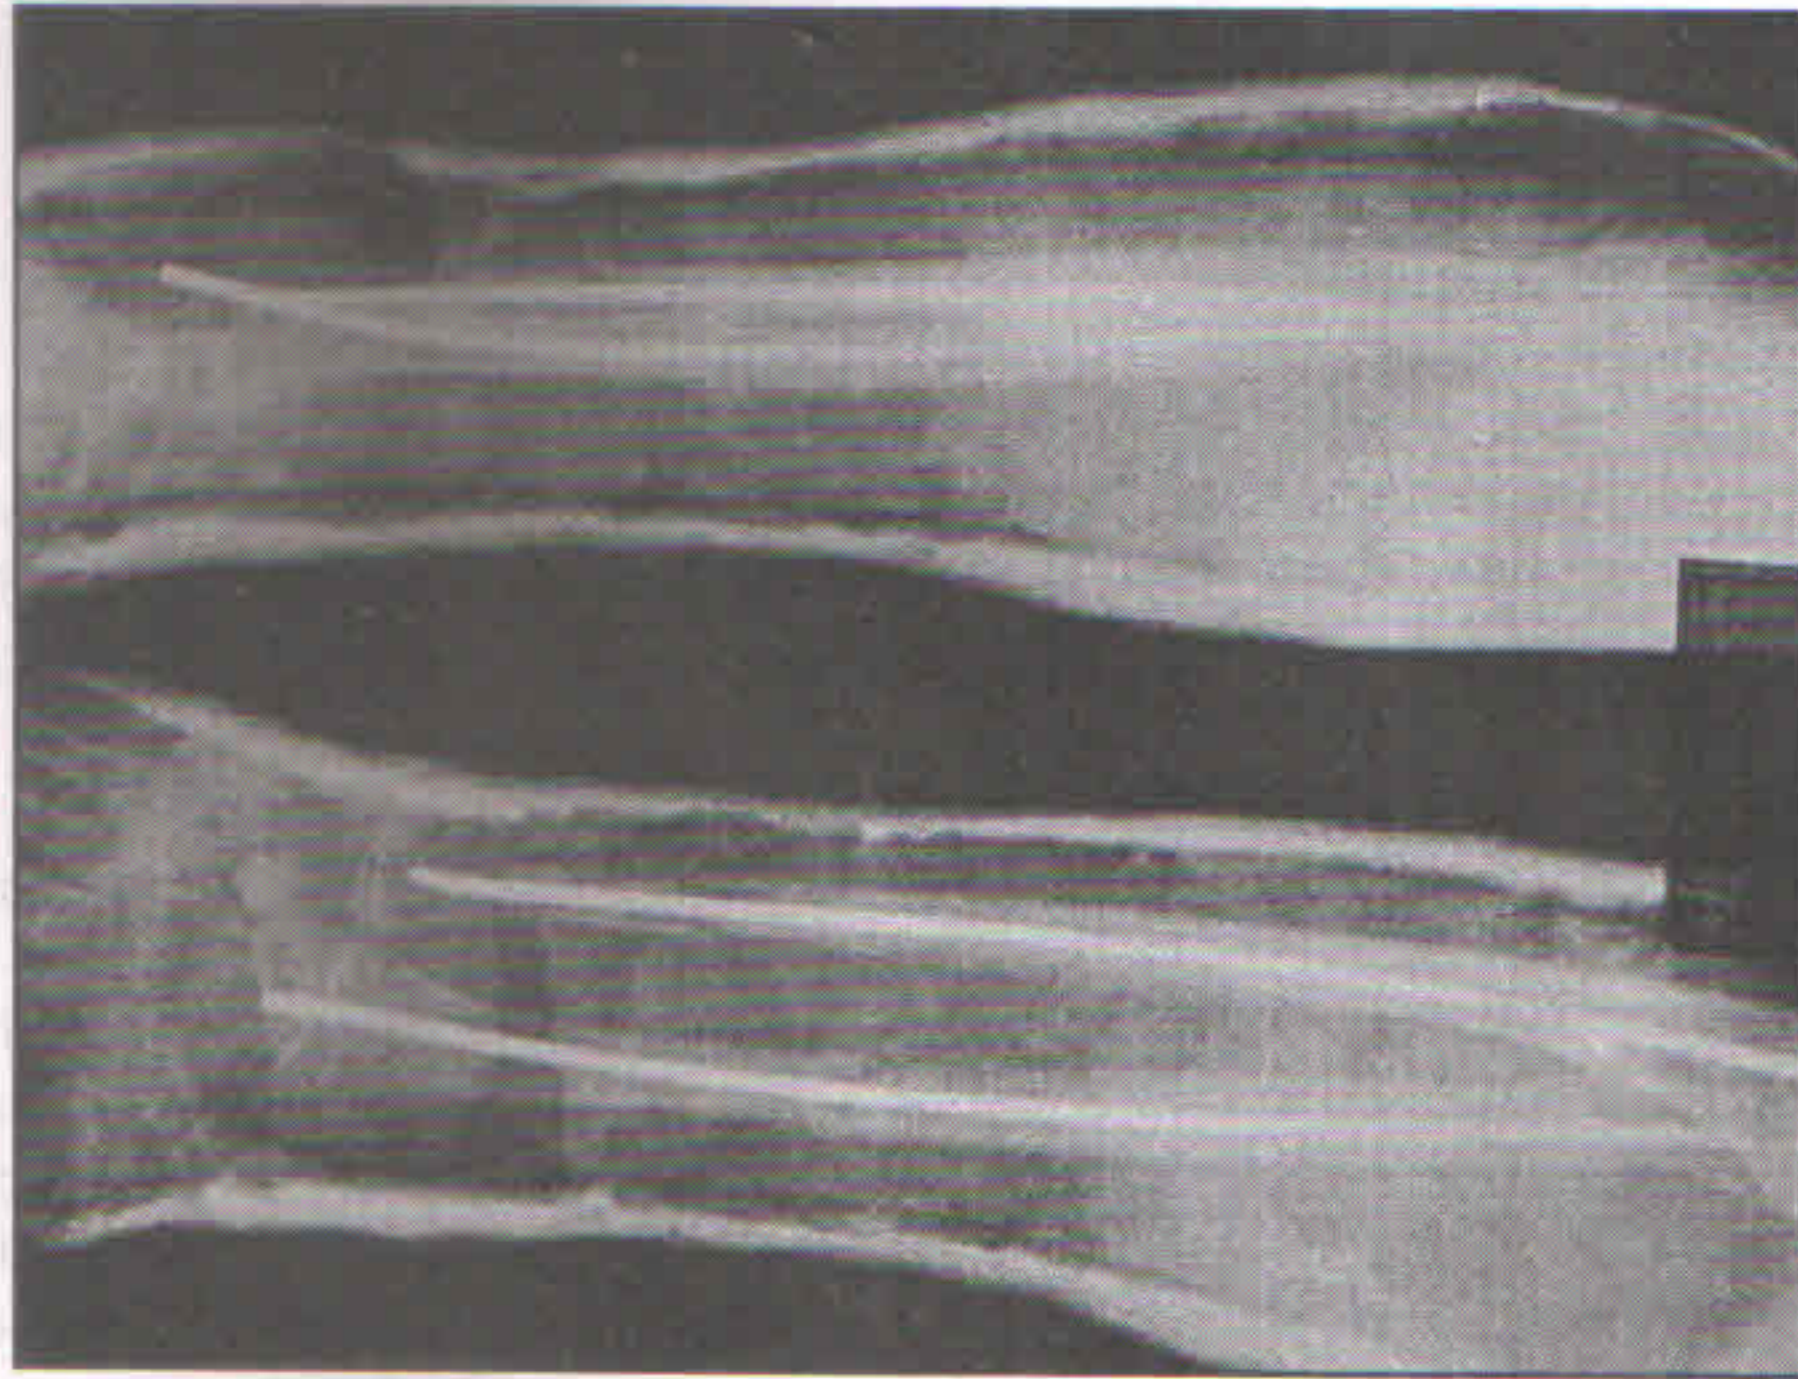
Immediate postop Xray showing elastic intramedullary nails in position
